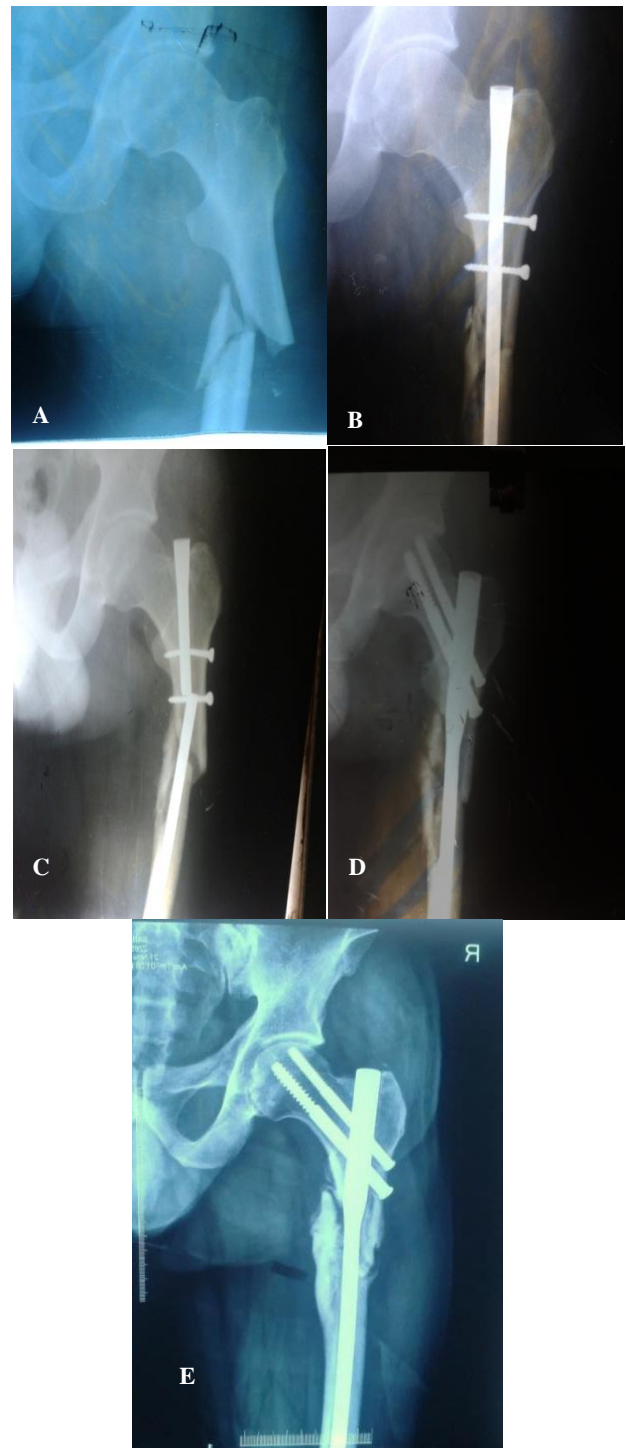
(A) Pre-operative X-ray, (B) post-operative X-ray, (C) X-ray with implant failure, (D) post-operative revision X-ray and (E) final follow-up with union.
